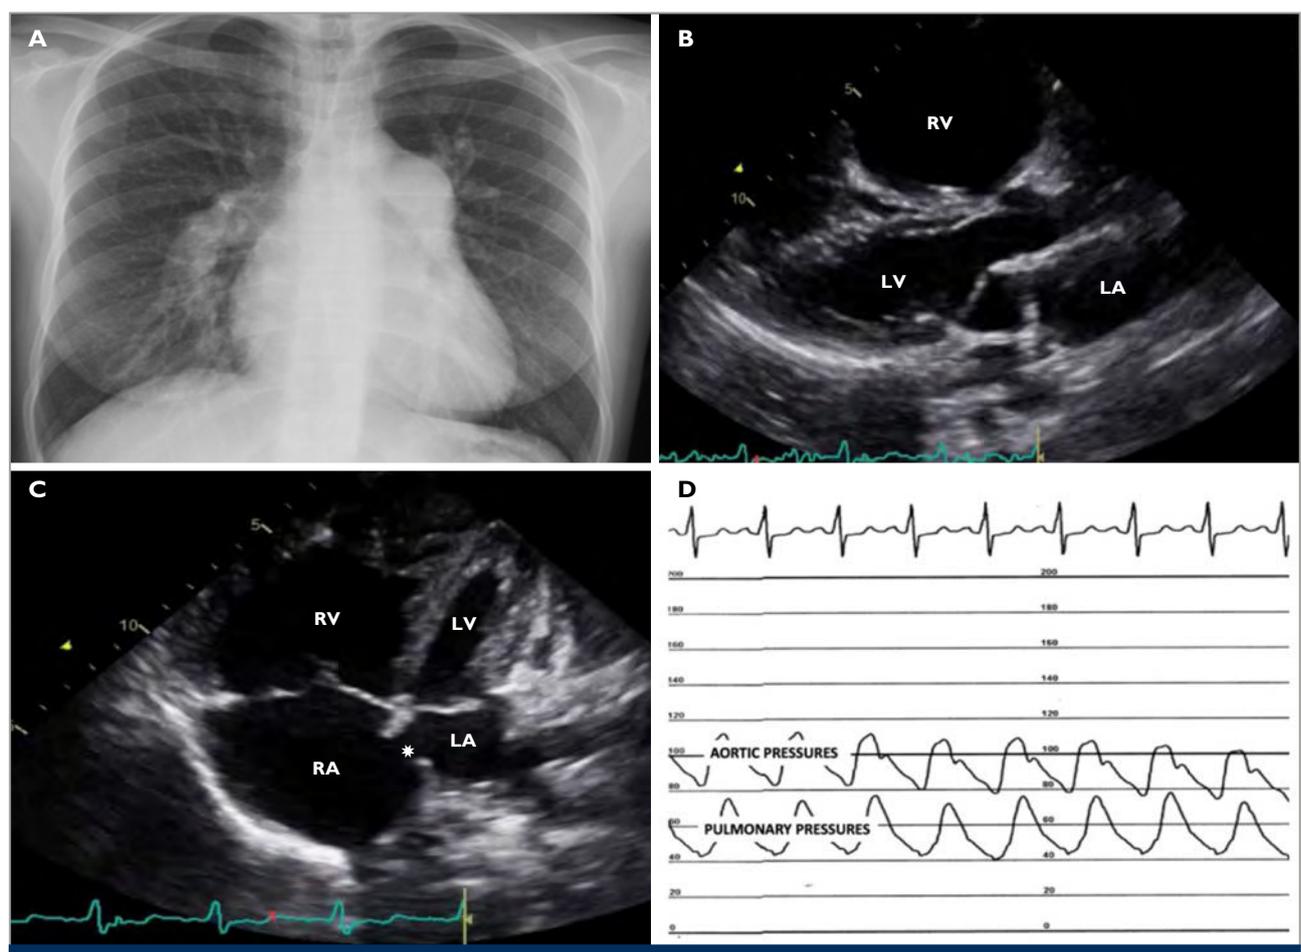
A 27-year-old patient, known with an atrial septal defect (ASD) presented with dyspnoea and pre-syncope at 15 weeks gestation. (A) Chest x-ray showed a normal cardio-thoracic ratio, markedly enlarged pulmonary arteries and plethoric lung fields. (B) A parasternal long axis shows a markedly dilated RV outflow tract and a pressure loaded RV. (C) The apical 4-chamber view shows a dilated RV and RA with a secundum ASD (white star). At cardiac catheterisation, severe pulmonary hypertension was noted. (D) The systolic pulmonary pressures were >2/3 of the systolic pressure.
